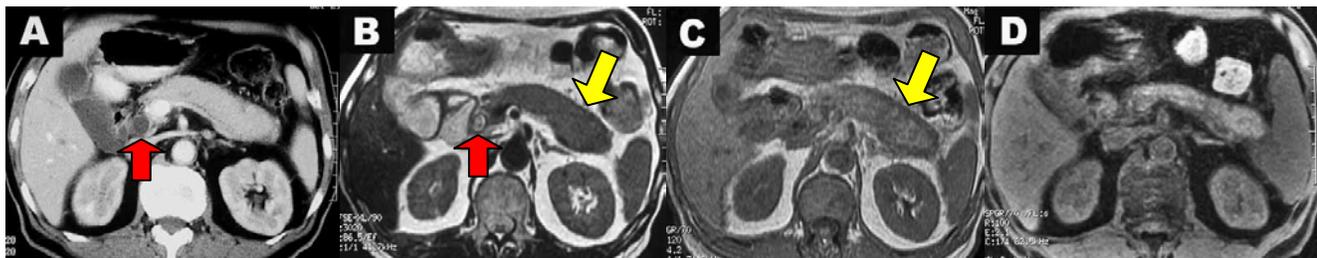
Figure A-D. Autoimmune pancreatitis in an 84-year-old man. Diffuse enlarged pancreas was showed on enhanced CT (A), FSE T2WI (B), and SPGR T1WI (C). A capsulelike dark rim (yellow arrows) around the pancreas was clearly demonstrated on FSE T2WI (B) and SPGR T1WI (C), but not on enhanced CT (A). Imaging abnormalities resolved on follow-up fat suppressed SPGR T1WI after 4 months of TCM therapy. Dilated bile duct (red arrows) was showed on Fig A and B.
